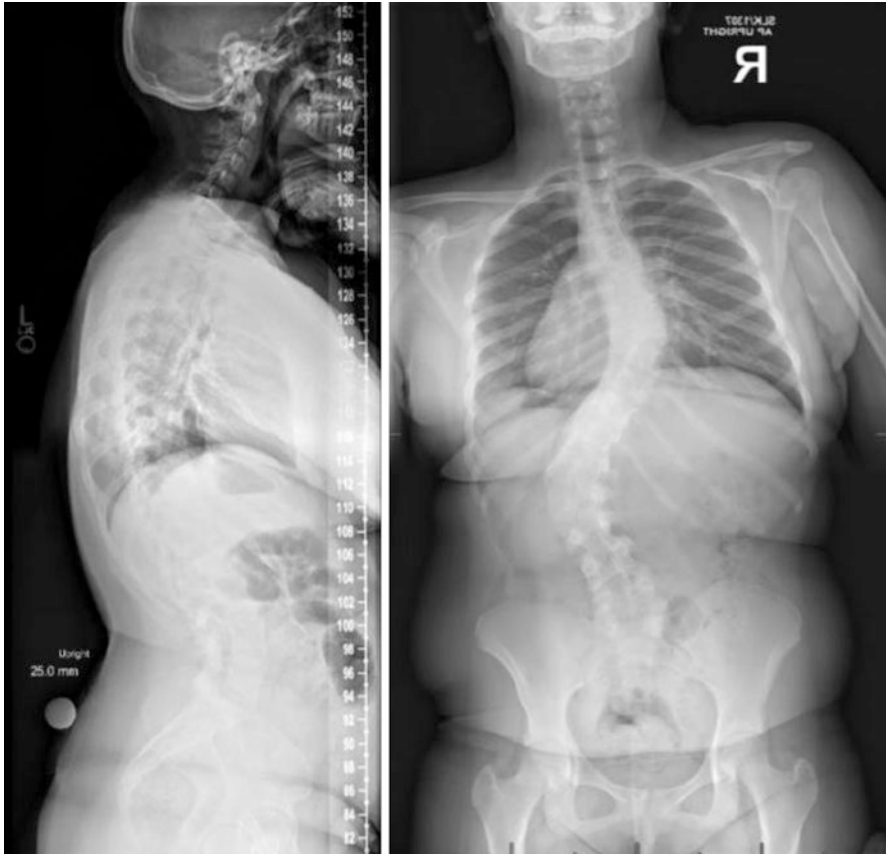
PA and lateral standing radiograph of a teenager with adolescent idiopathic scoliosis. Note that the entire spine and pelvis are included on this initial PA film
